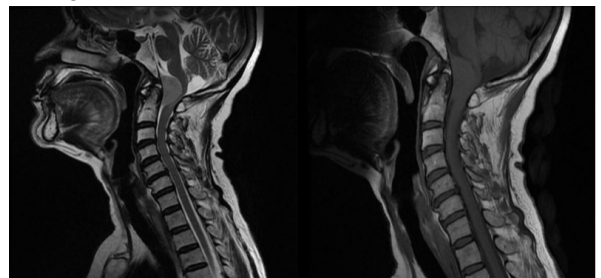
On sagittal non-contrast T2WI and T1WI MR images, the lesion appears iso-hyperintense on T2WI and iso-intense on T1WI.
